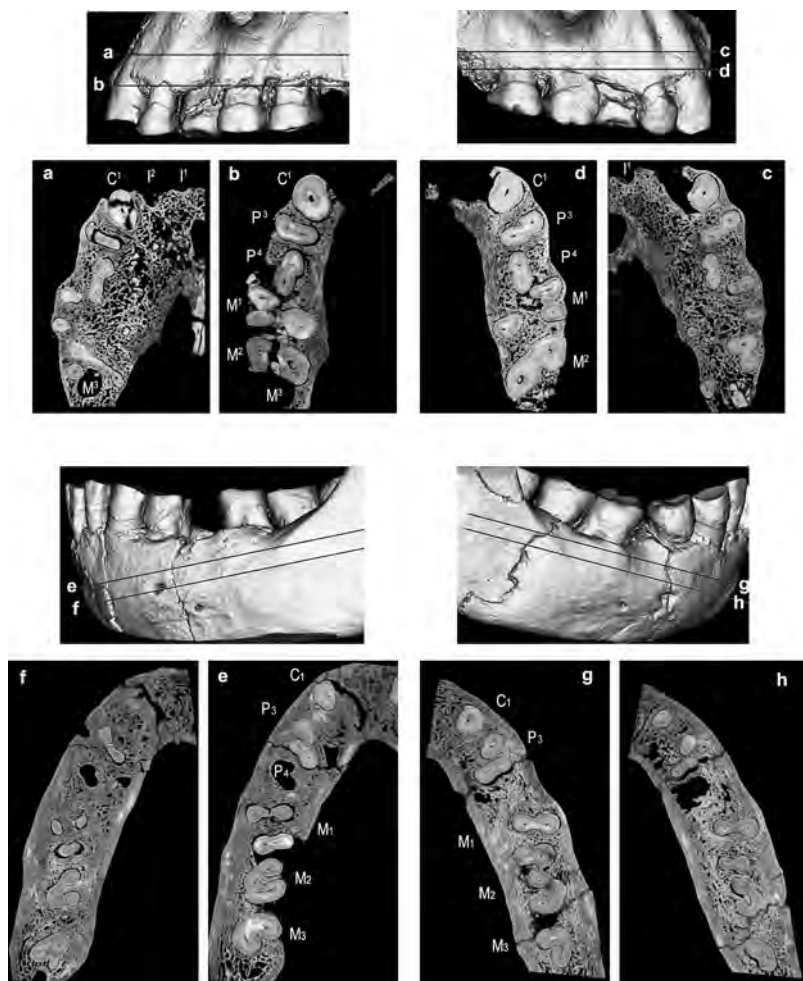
CT sections of the dental roots of LB1. The level for each section is indicated in the image above the relevant section. Upper left (sections a and b): left maxillary dentition. Upper right (sections c and d): right maxillary dentition. Lower left (sections e and f): left mandibular dentition. Lower right (sections g and h): right mandibular dentition.
